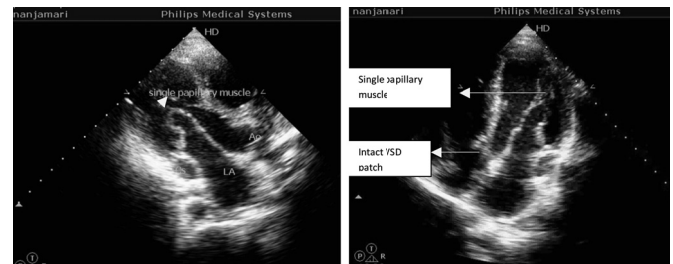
Left, Transthoracic ECHO, showing single papillary muscle (parasternal-short-axis-view). Right, Transthoracic ECHO, showing single papillary muscle (apical-four-chamber-view).
